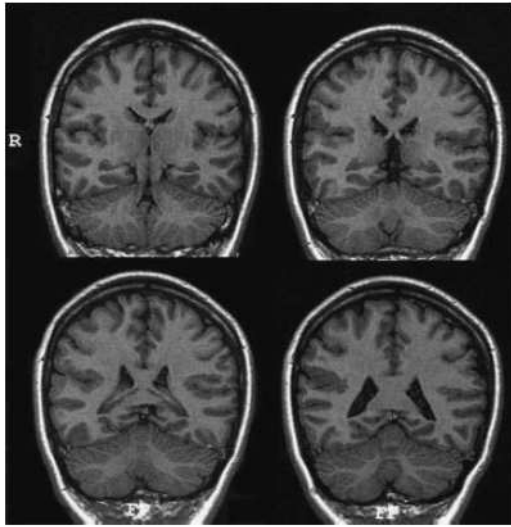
MRI from Patient II-4 (female). Coronal T1 images showing mild bilateral asymmetrical perisylvian polymicrogyria (more evident on the right side) which spares frontal and parietal lobes.
